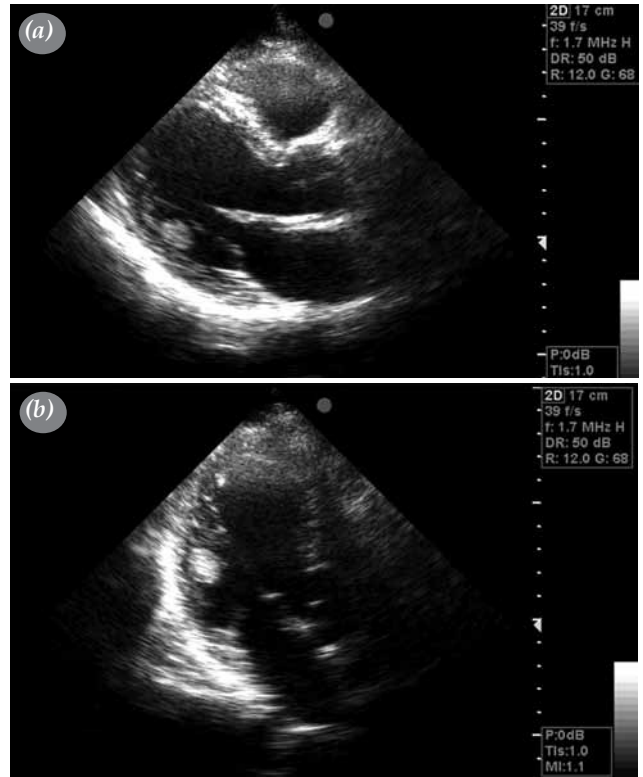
(a) Parasternal long axis view demonstrating the mass in the left ventricular cavity located between the posterior wall and the chordae tendineae. (b) Apical long axis view demonstrating the spherical hyperechogenic mass located beneath the posterior leaflet of the mitral valve.
